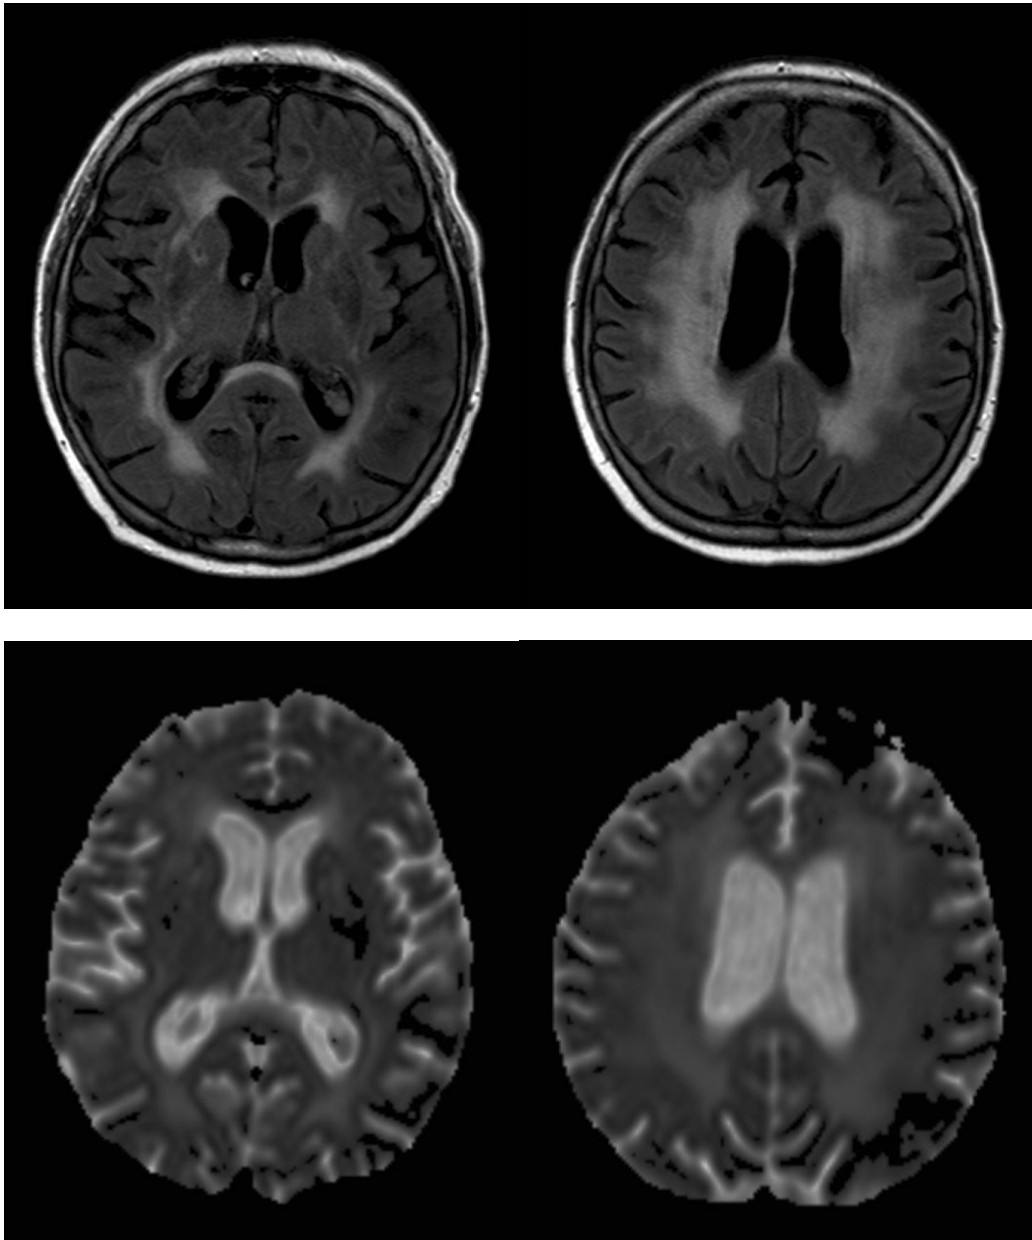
Diffuse white matter lesions in a 70 year-old hypertensive patient on axial FLAIR image (upper row) and ADC map (lower row). Note the increased diffusion (ADC) corresponding to areas of WMH (FLAIR).
